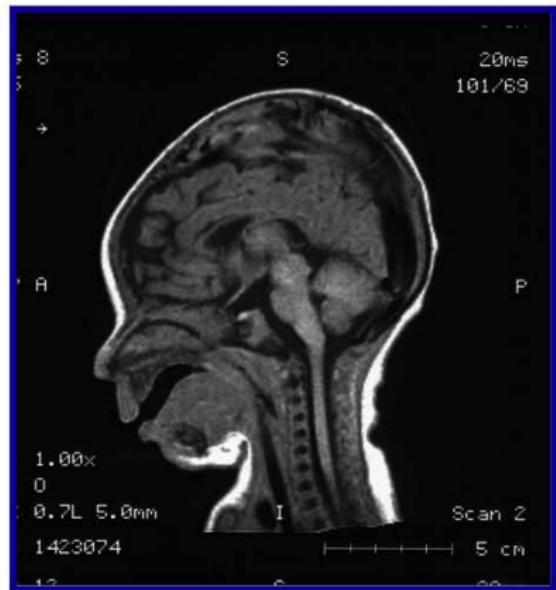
Male 2 week old infant MRI
